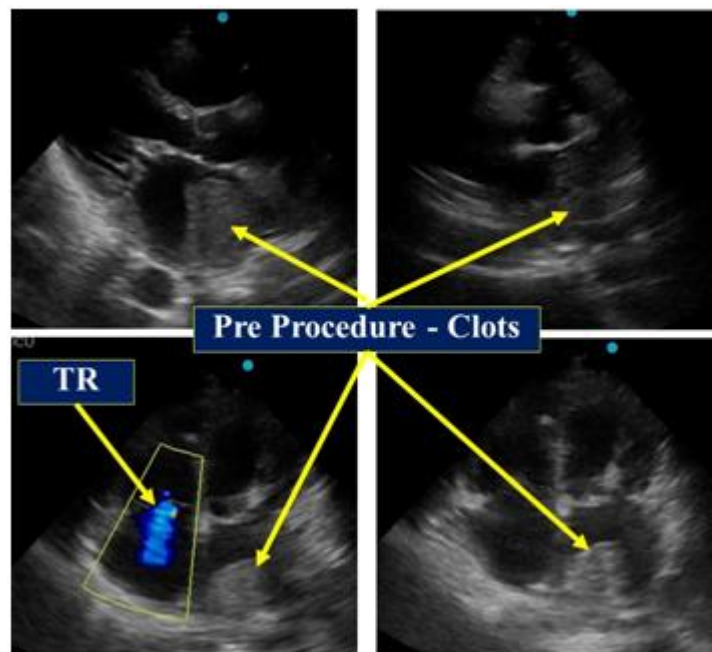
Pre Procedural 2D Echocardiographic Stills
